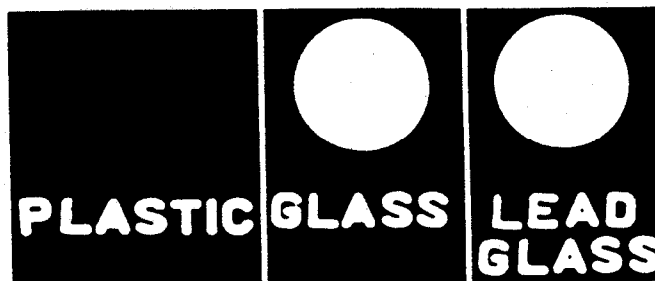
This radiograph shows the lucency of plastic, the lucent center of the glass lens, and the opacity of lead content glass.
